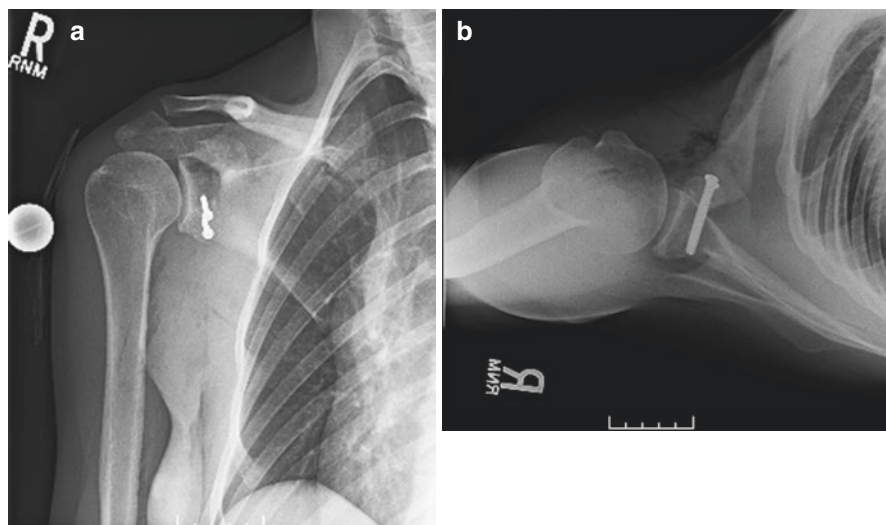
True AP (a) and axillary (b) radiographs of the shoulder showing the correct position of the transferred coracoid process on the anteroinferior glenoid
